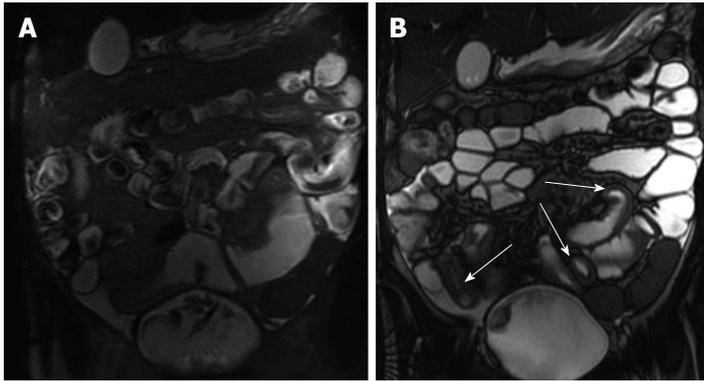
Type 2 Gluten-sensitive enteropathy (Celiac disease). A: Coronal T2-weighted single shot fast spin echo; B: Coronal balanced steady state free precession images show an abnormal ileal fold pattern with substantial decrease in the number of jejunal folds suggesting the diagnosis of celiac disease. Concomitantly, jejunal and ileal segments with increased mural thickening and stratification are seen (arrows, B), consistent with superimposed active inflammation.
